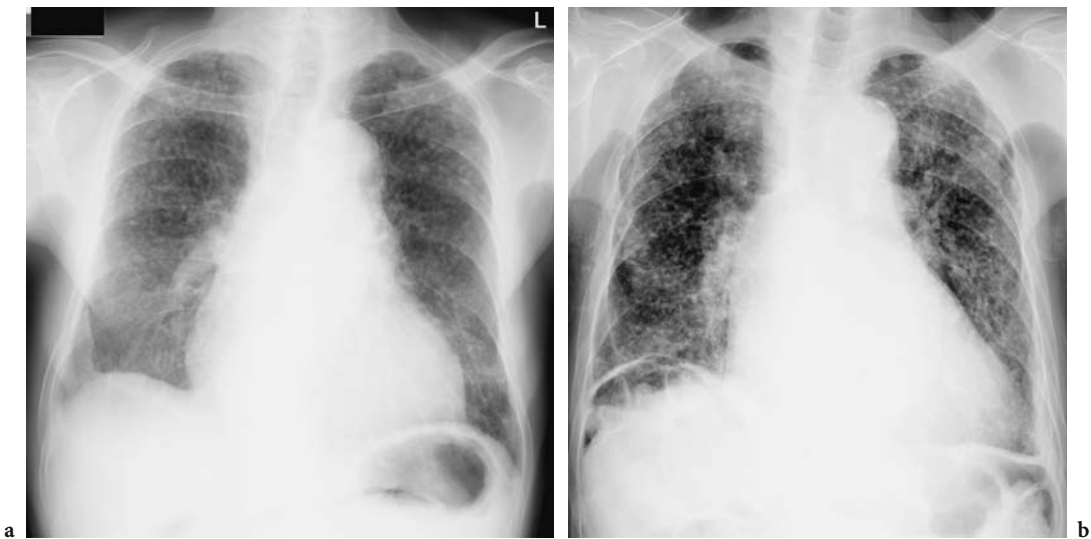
A 67-year-old old retired tunnel worker. a Posterior–anterior (PA) chest radiograph obtained in 2000 showing small nodules predominantly on the upper lobe. The nodule size and profusion are p/p and 1/1 respectively. b PA chest radiograph obtained in 2004 show progression in the profusion of the nodules from 1/1 to 2/2. There is also more prominent egg-shell calcification of enlarged hilar lymph nodes (*arrows*)
